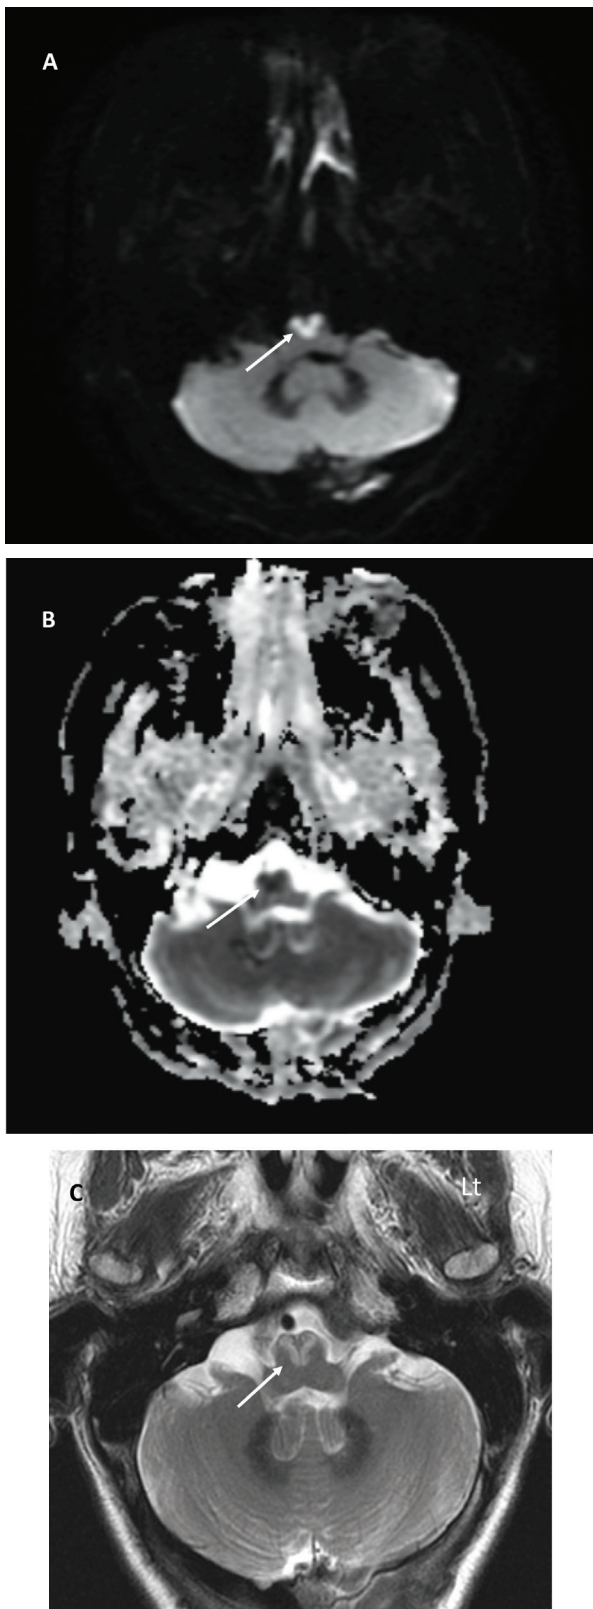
A) MRI of heart-shaped appearance (arrow) in ventral medulla in diffusion-weighted image; B) Apparent diffusion coefficient sequence; and C) T2-weighted sequence. MRI: Magnetic resonance image.
